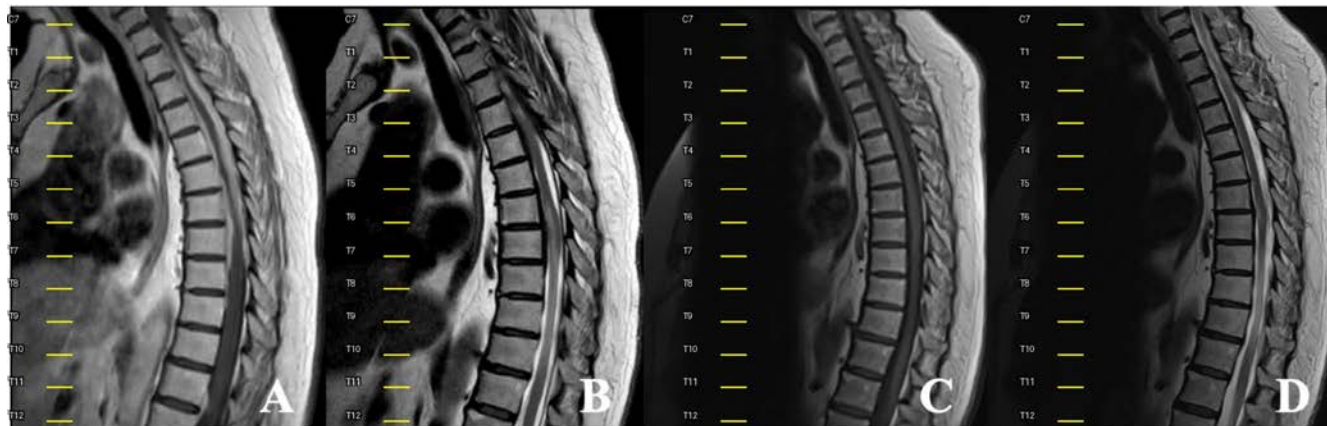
(A, B) Pre-treatment contrast-enhanced T1- and T2-weighted images; (C, D) non-contrast-enhanced T1- and T2-weighted images obtained 1 month after treatment, showing resolution of dural and intramedullary abnormalities.
